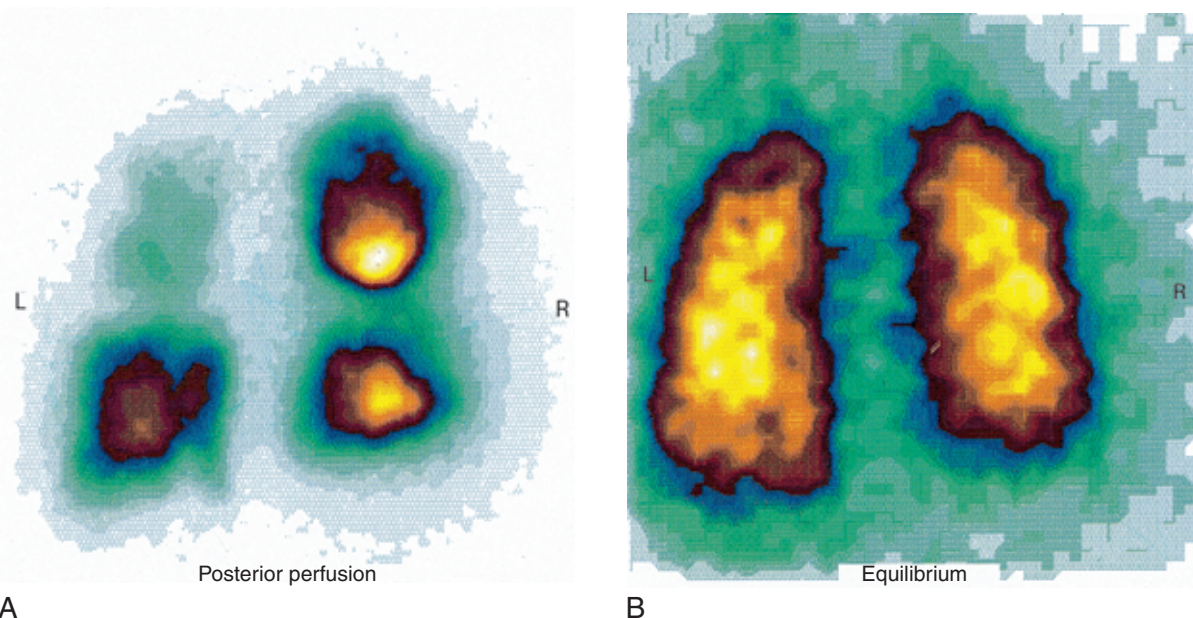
Lung ventilation and perfusion scintigraphy. A, Multiple perfusion defects in left upper lobe and right midzone on perfusion scan. B, Normal ventilation scan. This combination is consistent with high probability of pulmonary embolism. (From Haslett C, Chilvers ER, Boon NA, et al: *Davidson’s Principles and Practice of Medicine, 19th ed.*, New York, Churchill Livingstone, 2002, figure 13.6.)
